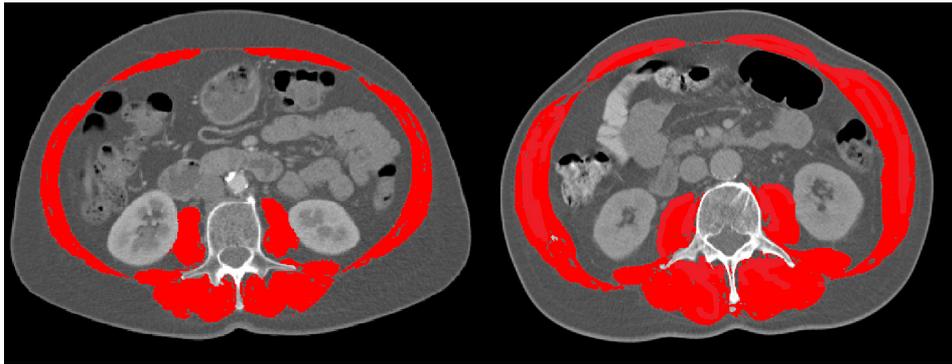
CT scans at the third lumbar vertebra level of a male patient with normal skeletal muscle mass (right) and decreased muscle mass (left)
